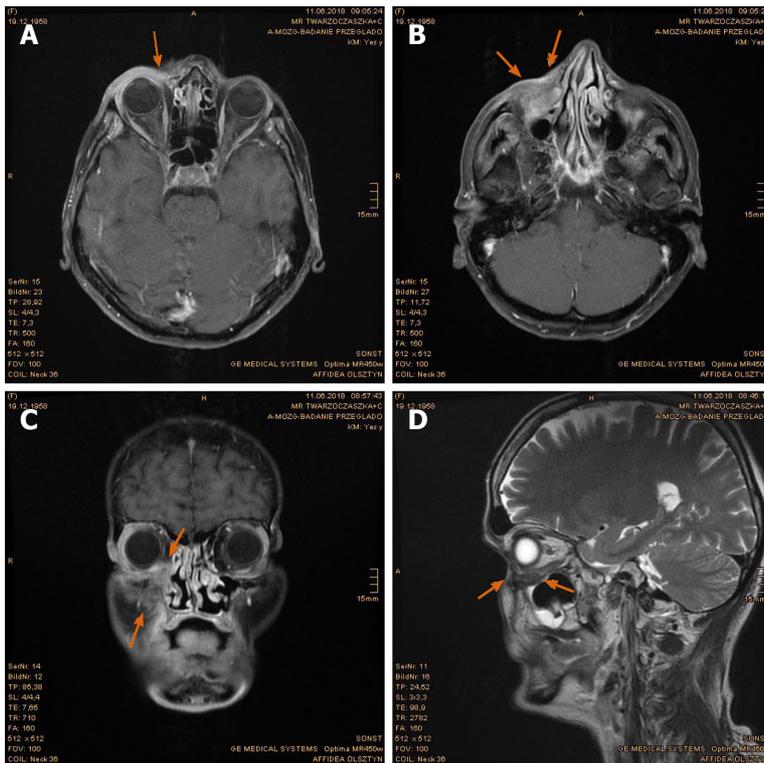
Pronounced tumor reduction in the first follow-up magnetic resonance imaging scan. A: Dwindling of enhancing tumor nodules at the right naso-orbital corner; B: Decreased enhancement in the soft tissue of the naso-labial fold and zygomatic area; C: Significant regression of the right periorbital sinonasal cancer, presented in coronal plane; D: Restored delimitation of the right orbital floor, presented in sagittal plane. Former tumor extent marked with arrows.
